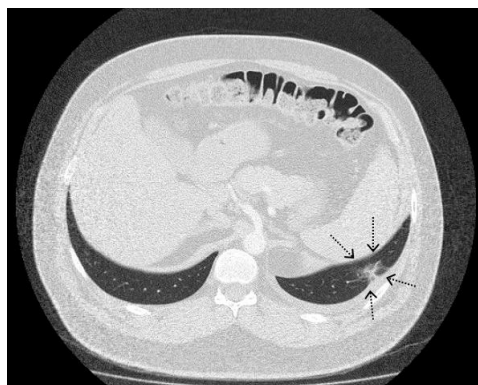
Thorax CT showing patchy consolidation at the posterobasal segment of left lung (black dotted arrows).
